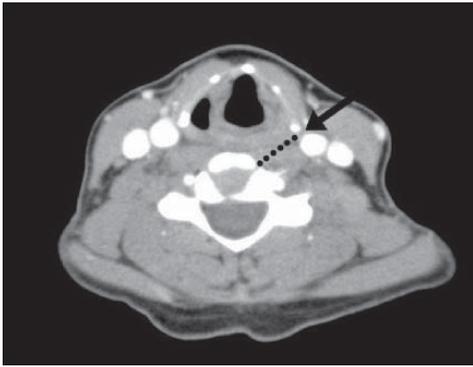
Axial CT localisation scan at the C5-C6 disc level with intravenous contrast administered to identify vascular structures and for planning of needle trajectory. The narrow gap between the thyroid cartilage and the carotid artery and jugular vein is noted (black arrow), with the planned needle track leading into the cervical disc space (black dotted line).
